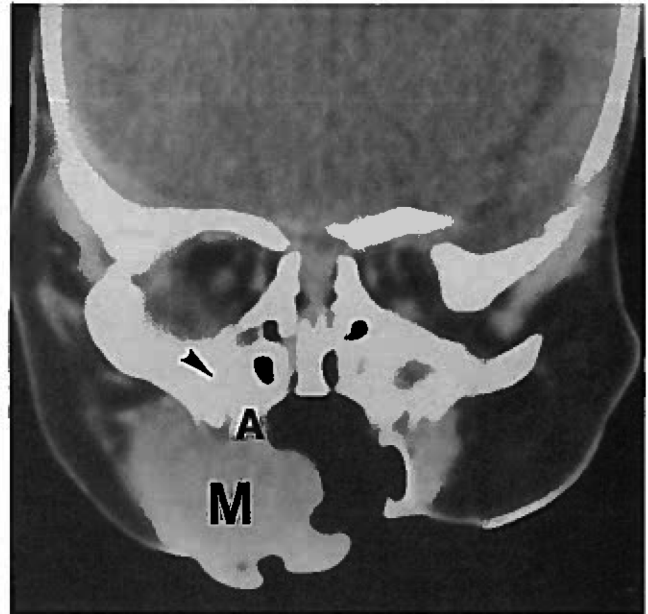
Coronal computed tomography scan through the face shows a lobulated soft tissue mass (M) extending from the right superior alveolar ridge (A). Arrowhead indicates a small tooth bud.
